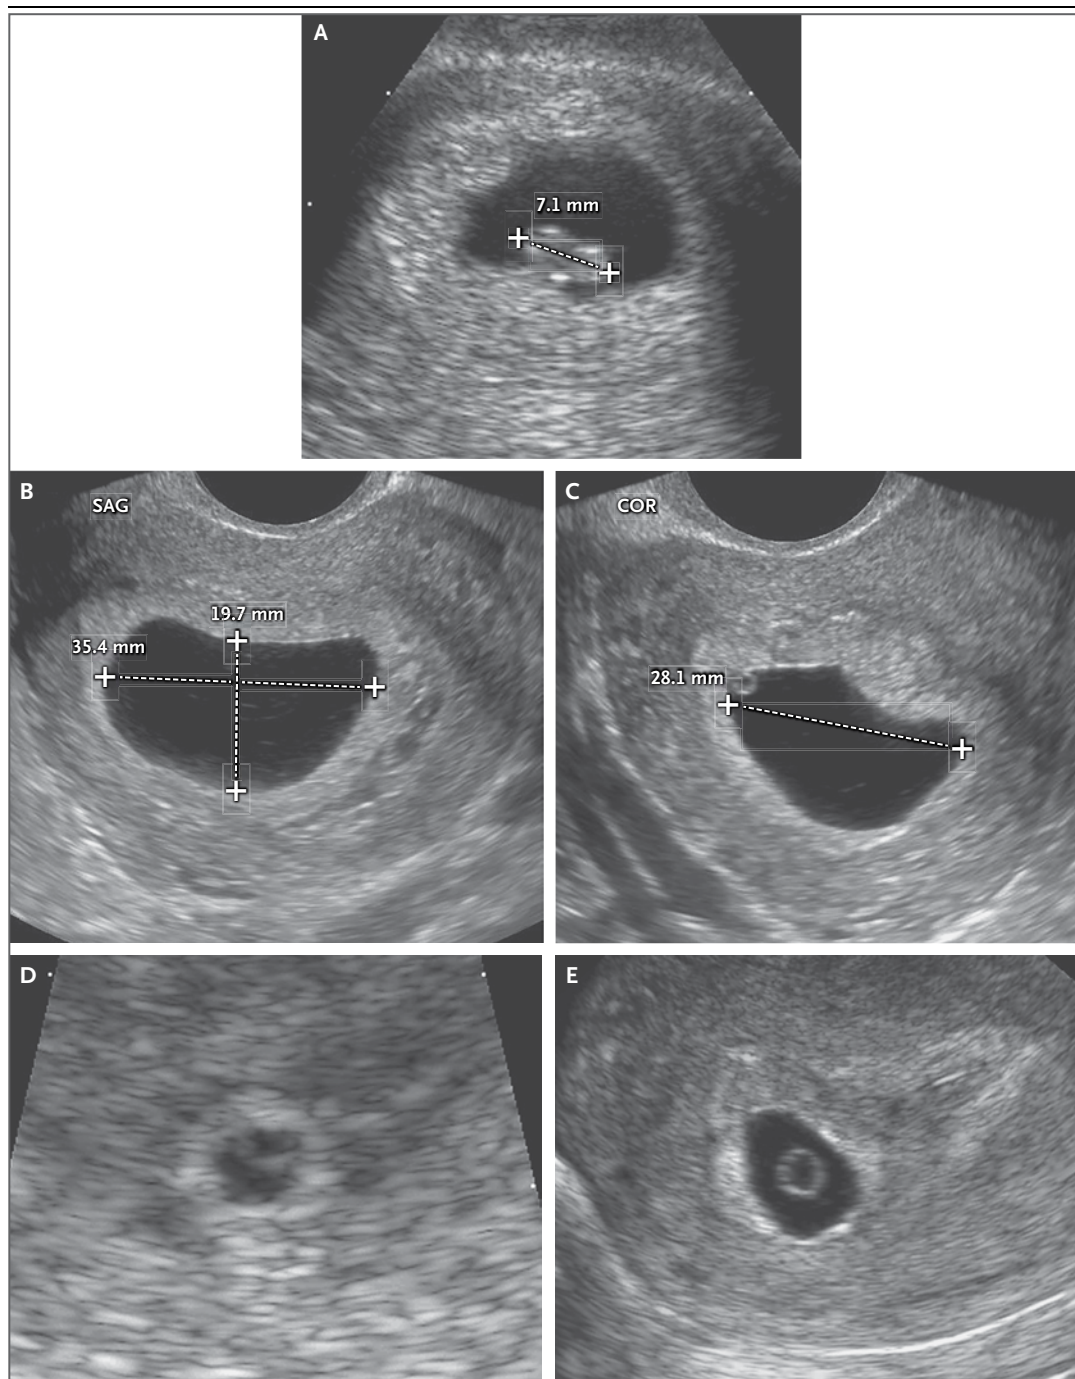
Definite Pregnancy Failure Diagnosed in Three Women by Means of Transvaginal Ultrasonography.
